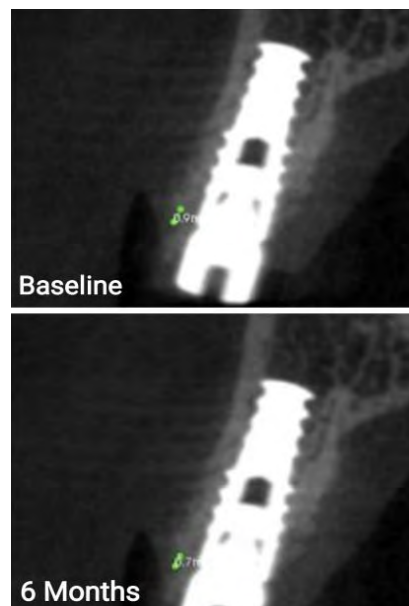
Vertical CBCT measurements recorded at Baseline (Day 0) and 6 Months
